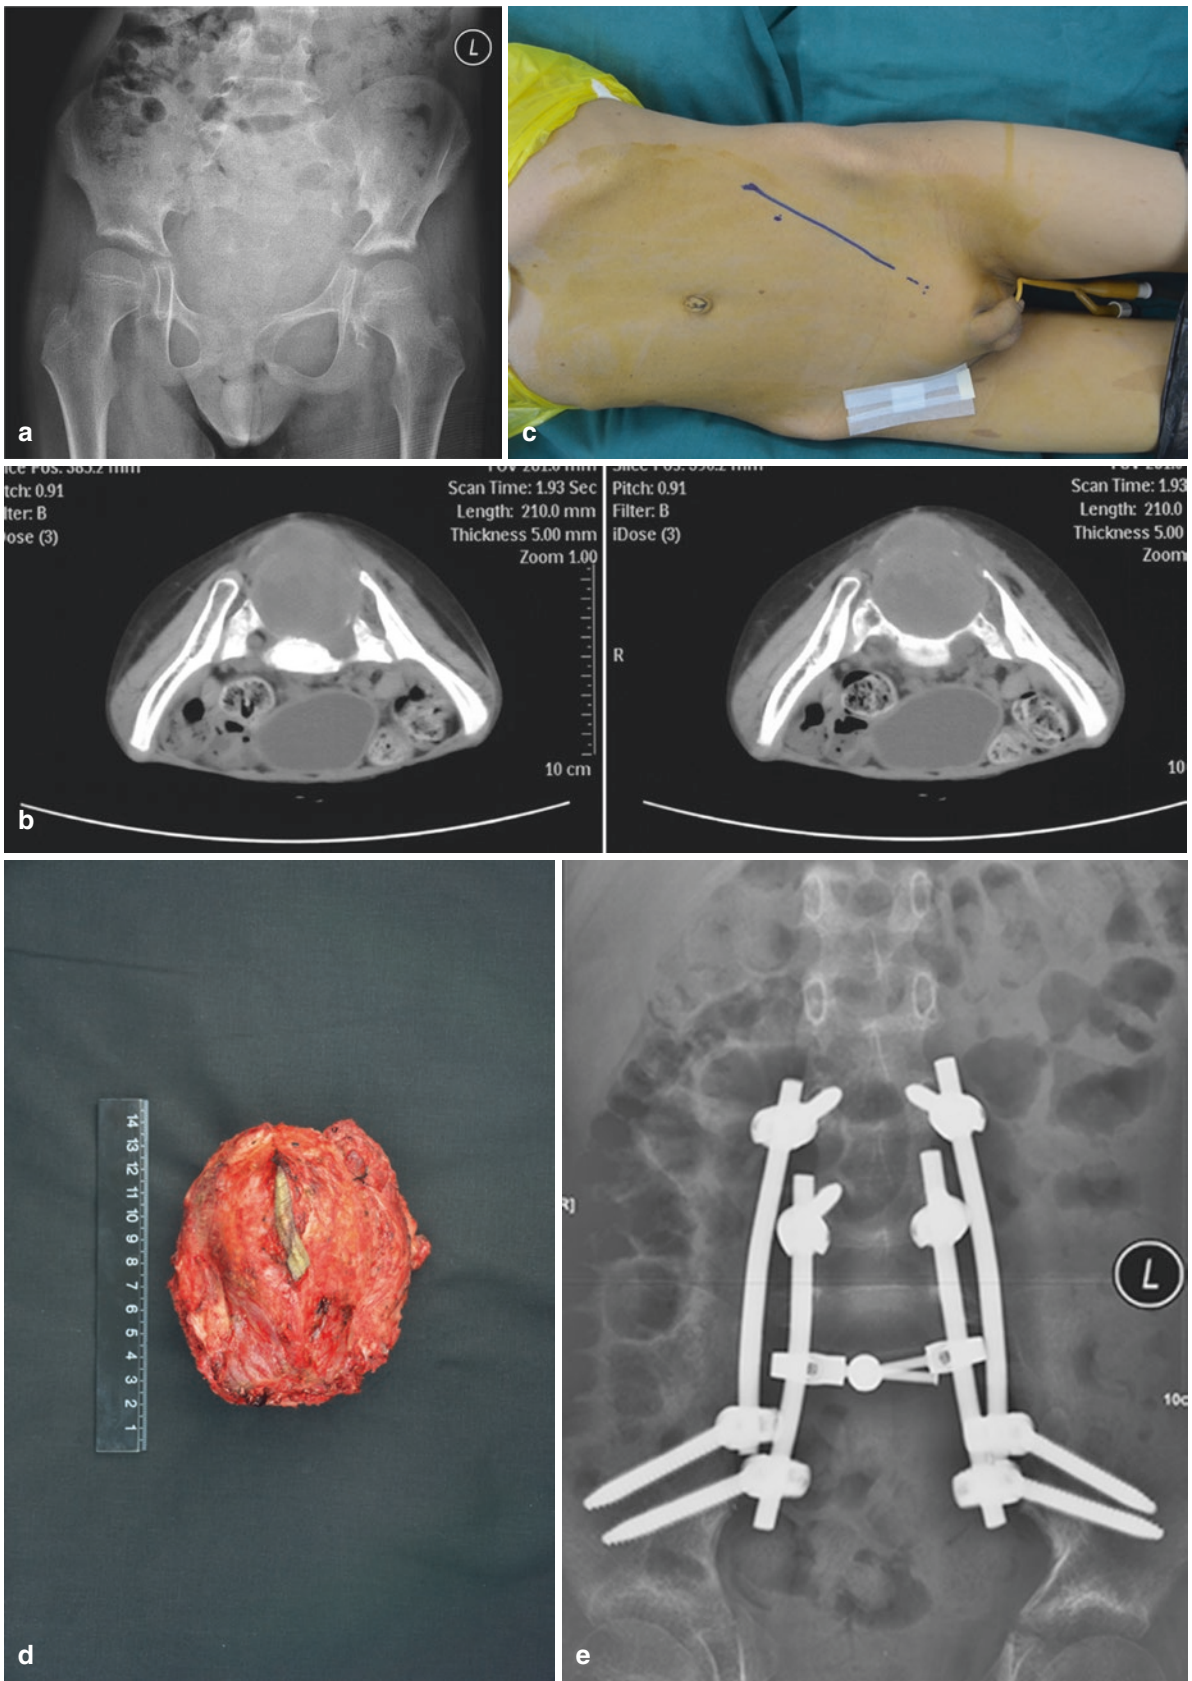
(a–e) A male patient with malignant peripheral nerve sheath tumor involving the sacrum treated with total sacrectomy. (a) Plain film revealing osteolysis in the sacrum. (b) CT image revealing a soft tissue
